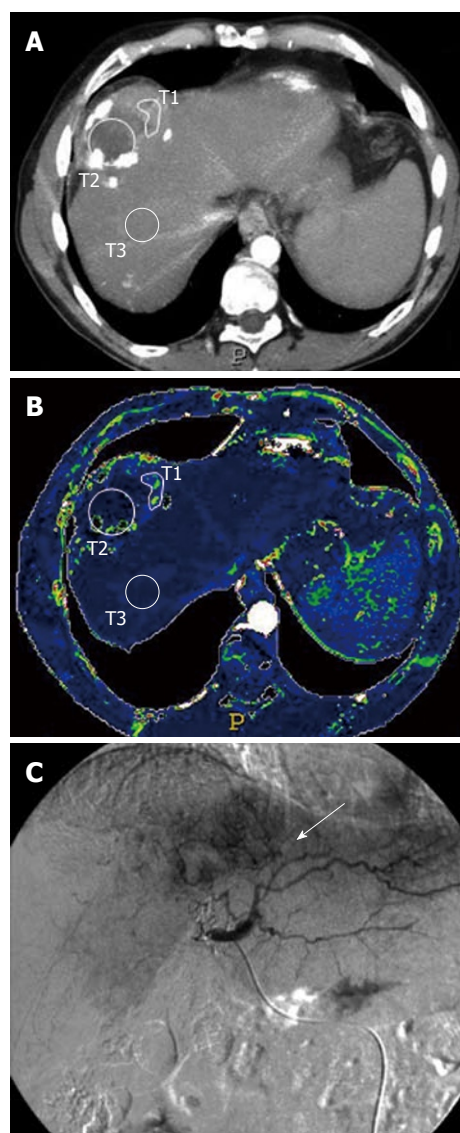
A 57-year-old man with Child B liver cirrhosis and 42 mm lesion of hepatocellular carcinoma in the fourth segment of the liver that underwent computed tomography-perfusion study. A: Transverse data raw multiphasic multidetector computed tomography scan image shows regions of interest (ROIs) positioned on the periphery of lesion (T2), and on the primary lesion without relapse (T1) and on the surrounding liver parenchyma (T3) avoiding vessel structures, in order to obtain the quantitative perfusion data of the regions; B: Functional arterial perfusion colour map shows that the distribution of perfusion in the treated lesion is heterogeneous, with a different range of colours of residual disease (T1) compared with primary lesion without relapse (T2) that reveal the unsuccessful treatment of transarterial chemoembolization; ROIs were also positioned at the same level in surrounding liver parenchyma (T3); C: Post chemoembolization digital fluoroscopic image obtained in the same patient shows disomogeneous distribution of the iodized lipiodol-chemotherapy mixture, with presence of hypervascular region (arrow) at the periphery of treated lesion, demonstrating the viable portion of tumour.
